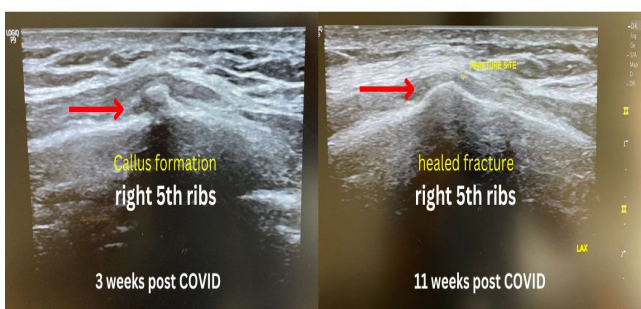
The left image is captured at 3rd week post Covid, showing a callus formation (red arrow) at the 5th ribs in a long axis view, and sono-palpation elicit similar pain. The ultrasound was repeated at 11th week post COVID (image on the right) showing healed rib fracture (red arrow) and absence of tenderness on sono-palpation.
